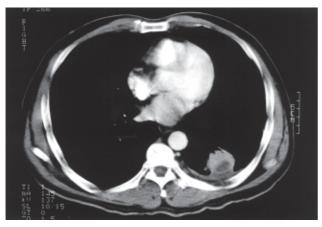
Computed tomographic scan of the thorax after 12 months treatment
